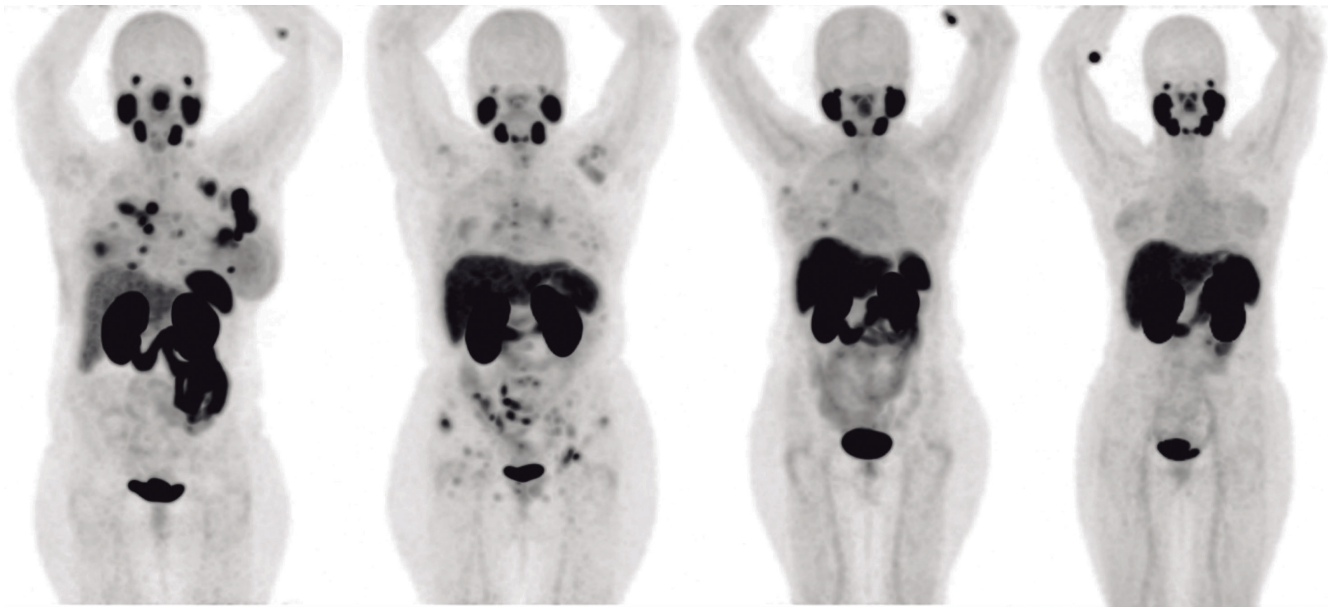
Aspect of 68Ga-PSMA uptake, compared to liver uptake, in MIP images of different patients
